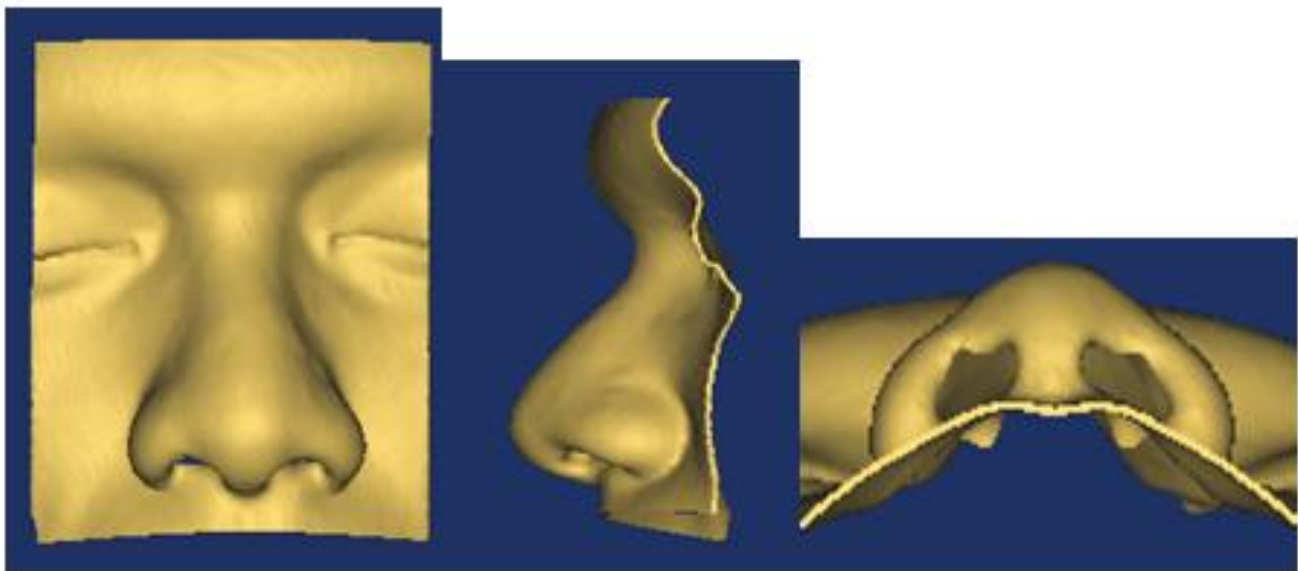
The frontal, lateral and basal view of 3D nose model generated from CT data
